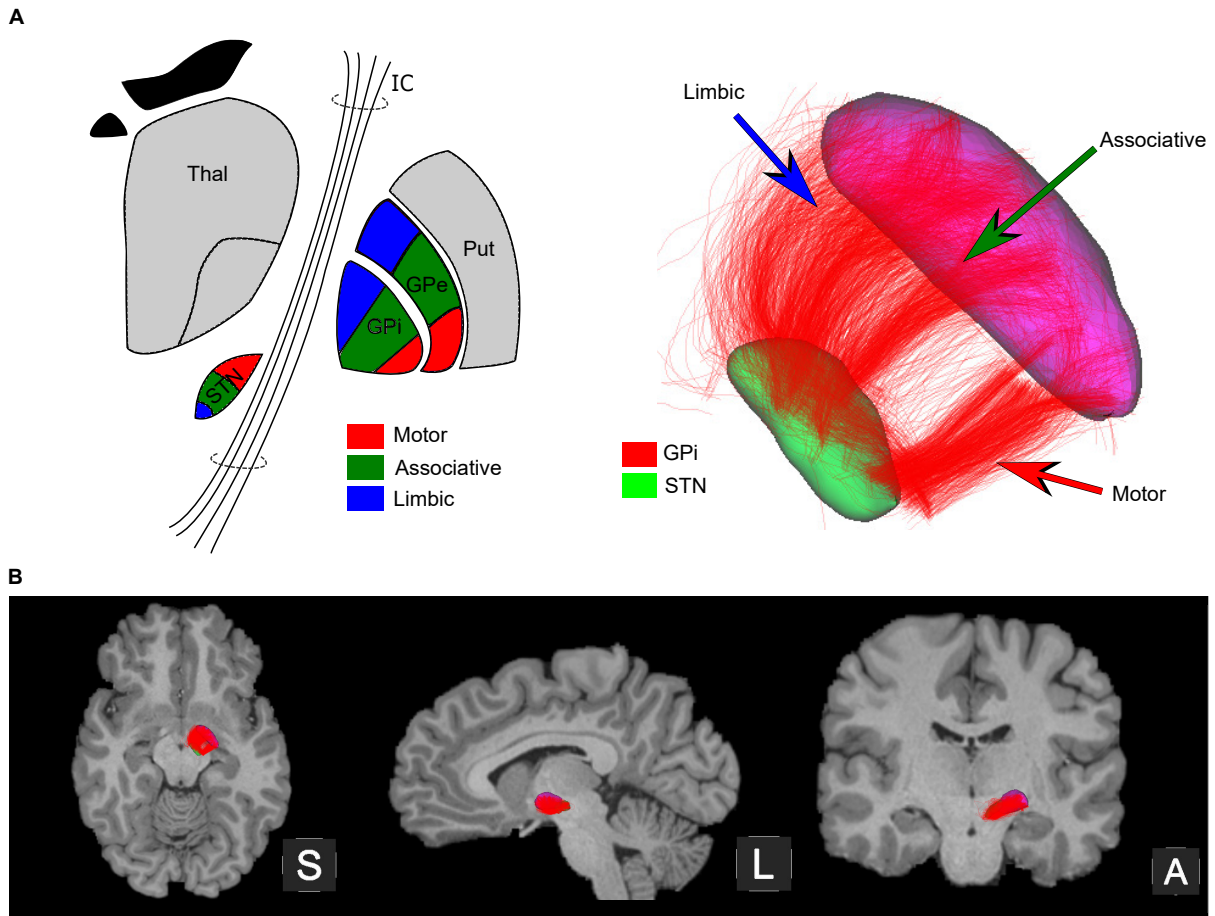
A single subject example of a connection found between the globus pallidus internal segment (GPi) and subthalamic nucleus (STN). For visualization purposes, refinement of tractography was performed and opacity was reduced to 20% to highlight the different segments observed. (A) Depiction of the approximate regions associated with different networks (e.g. motor, associative, limbic), identified from the literature (left) is shown for the STN and both internal and external segments of the globus pallidus: motor (red), associative (green), limbic (blue). Tractography identified trajectories (right) between the STN and GPi are shown from an inferior-to-superior (ventral) view, highlighting the different components associated with each network. (B) Three views (from left to right): superior, sagittal left, and coronal anterior exhibiting the connectivity between GPi and STN overlaid on a T1-weighted anatomical image.
